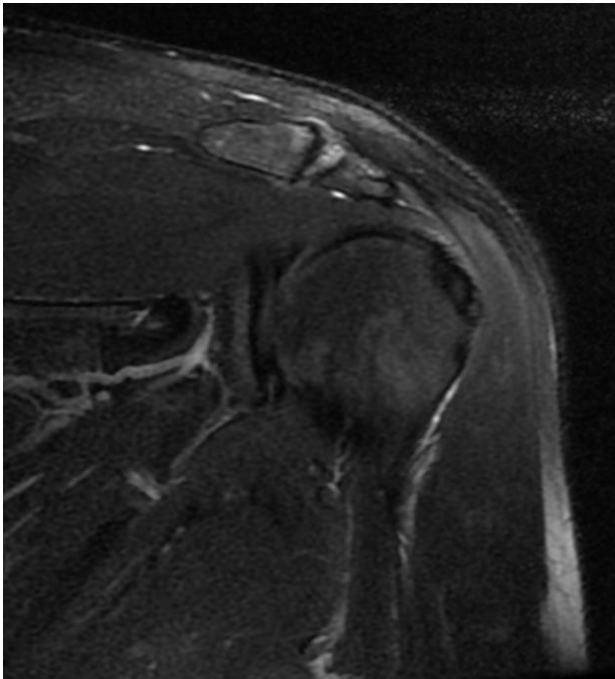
Reactive arthritis was diagnosed based on the increased effusion in the Acromioclavicular joint shown in the shoulder MRI.
